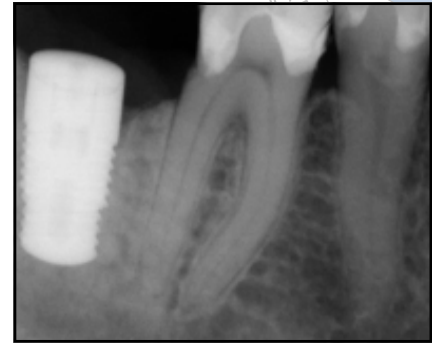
(left) Radiograph taken after placement of the first dental implant.
